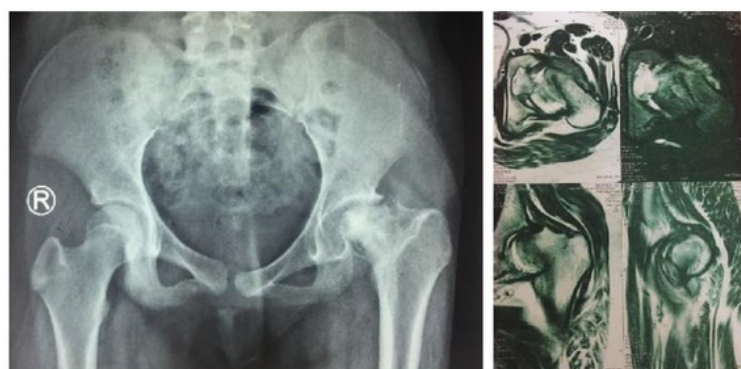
Right: (a) X-ray of pelvic view: migration proximally of the femur and collapse of the head of the femur; (b) left MRI deformity, subluxation, and impaction of the femoral head toward the superior and synovitis of left hip enhanced by contrast administration.
